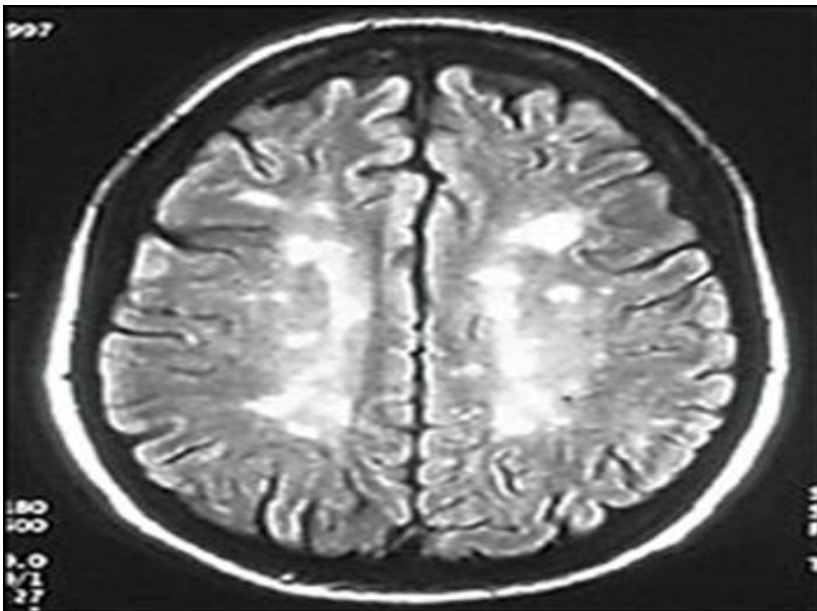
Fluid attenuation inversion recovery (FLAIR) transverse section image of the brain with multiple sclerosis. The lesions are shown in high signal white matter and periventricular region (Double Inversion Recovery Brain Imaging at 3T: Diagnostic Value in the Detection of Multiple Sclerosis Lesions, 2007)
